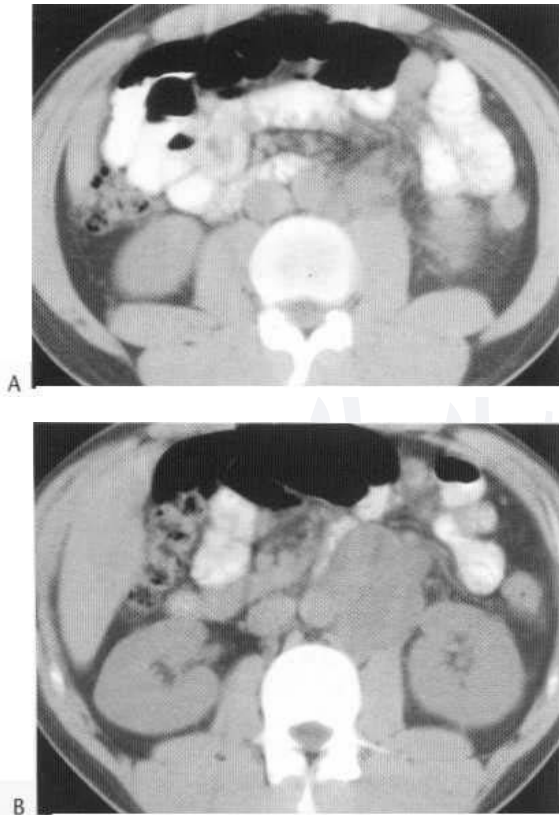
CT demonstrating para-aortic metastases from a left testicular malignancy. (A) At this level a small lymph node deposit is seen immediately lateral to the aorta and a larger one is visible anterior to the left psoas muscle. Higher up (B), just below the level of the renal hila, there is a large left-sided metastatic mass partly encasing the aorta.
